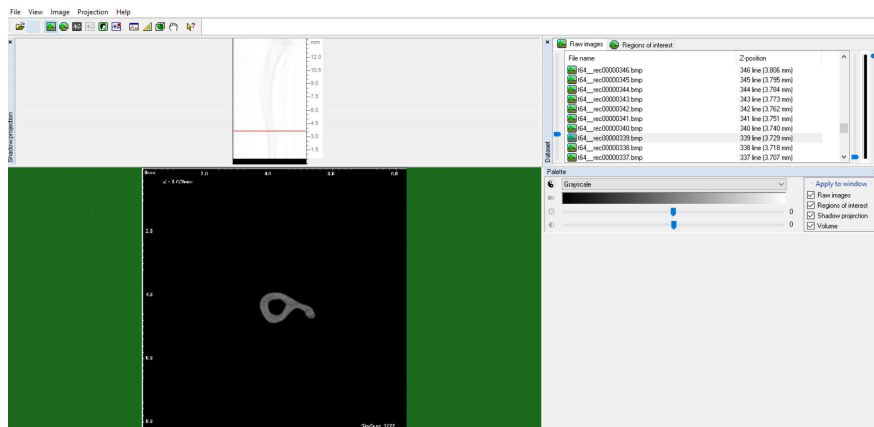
Images were analysed with a CT Analyzer (version 1.17.7.2, SkyScan).
